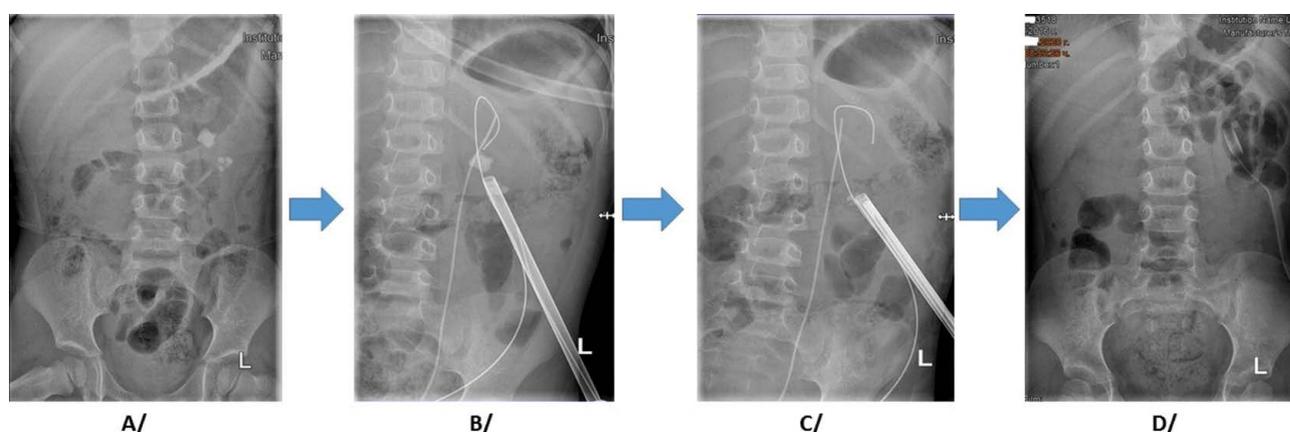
Radiographic images during the different stages of PCNL in a pediatric patient (4 years old) with multiple kidney stones on the left side: A. preoperative imaging; B, C. during PCNL; D. “stone free” after the procedure (with nephrostomy catheter).
